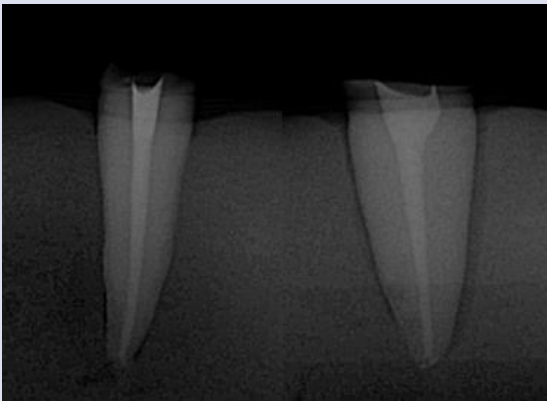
Radiographs of root canal filled with CH
